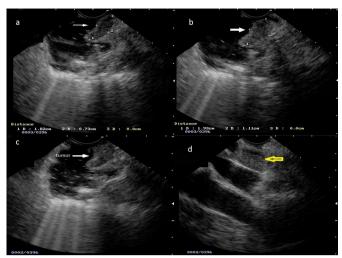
Endoscopic ultrasound. Hypoechoic and homogeneous area with precise limits (white arrows) in duodenal papilla measuring 1.82x0.73 (major axes) (a, b and c). In the image d the yellow arrow points to a perilesional lymph node that was biopsied with a 22G needle, just before the endoscopic papillectomy.
